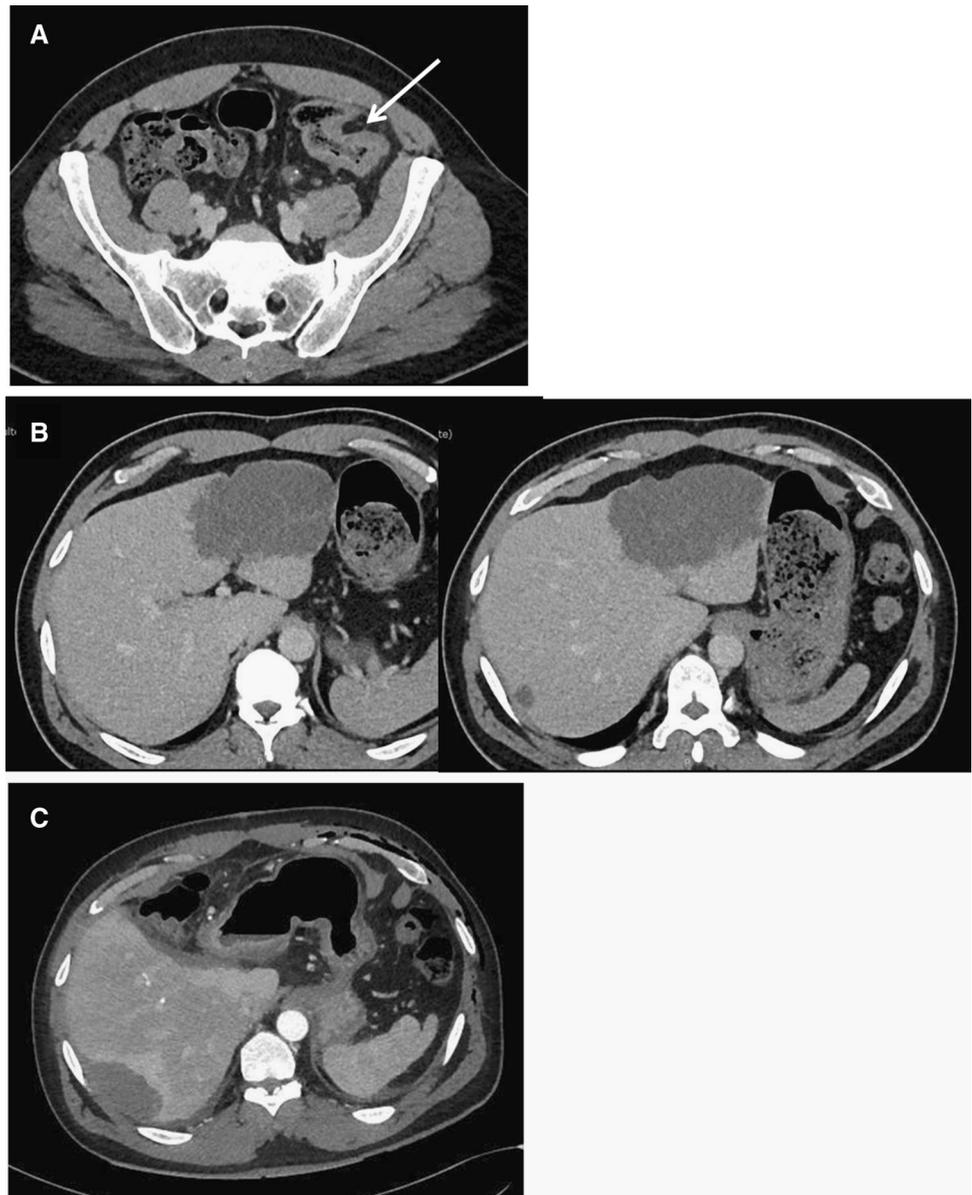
a, b Sigmoid colon adenocarcinoma (white arrow) and synchronous liver metastases on CT scan after FOLFIRINOX chemotherapy. c Postoperative day 6 control CT scan after laparoscopic liver resection and ablation of the segment VII lesion, and before the laparoscopic sigmoid resection
